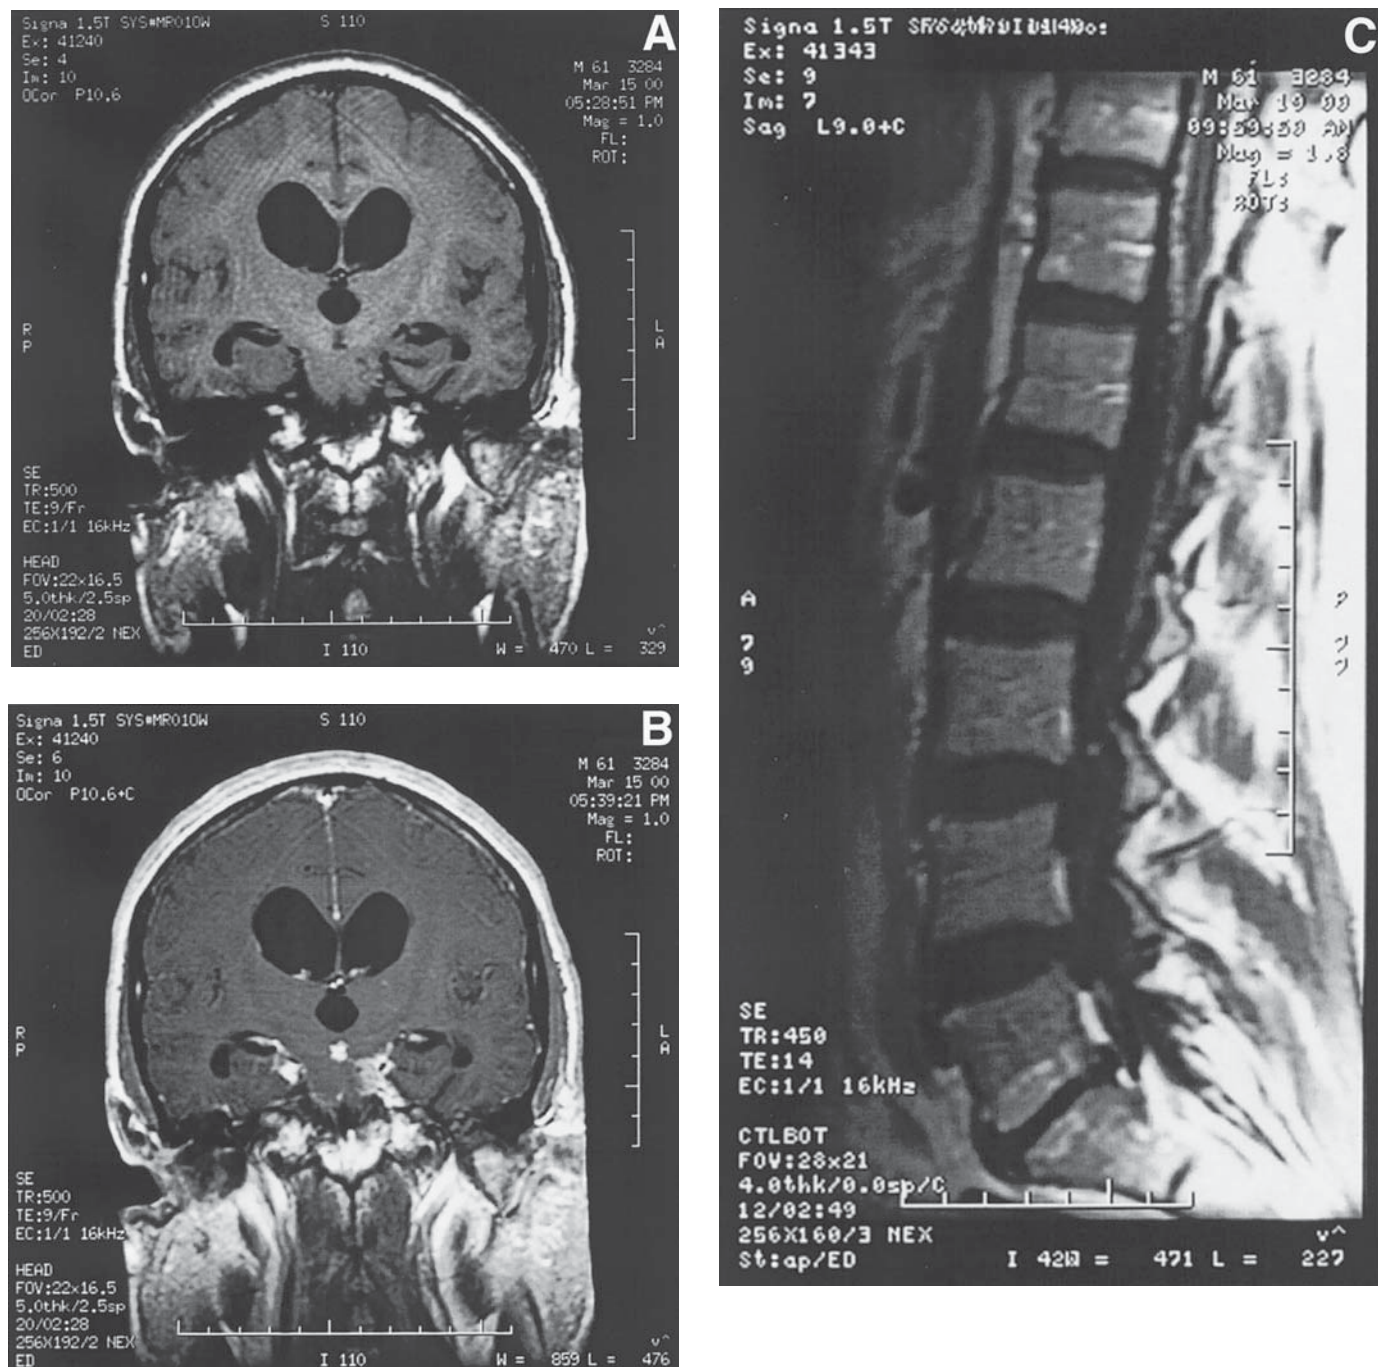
This man was diagnosed with a cerebellar hemangioblastoma 8 yr previously and was treated with surgery but no other therapy. He had a 6 mo history of severe headaches and lethargy. He felt nauseated and the headaches were described as being all over the head. (A) and (B) show unenhanced and enhanced coronal MRI images indicating diffuse meningeal enhancement and communicating hydrocephalus. (C) shows patchy enhancement around the cauda equina consistent with leptomeningeal metastases. Biopsy and pathology review confirmed a recurrence of his hemangioblastoma with leptomeningeal spread of disease, which caused his severe headaches. Radiotherapy (4500 cGy in 25 fractions) was administered to the whole brain for palliation and his headaches improved.
